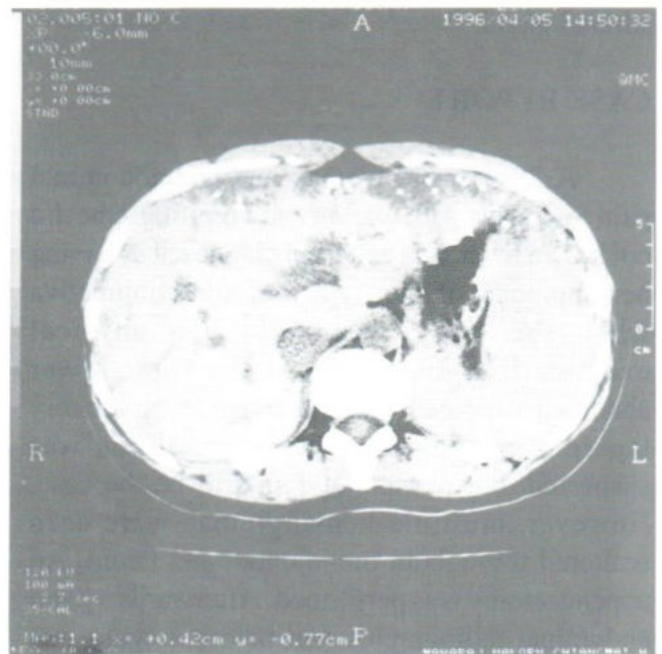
Precontrast CT scan shows multiple hypodense masses in the liver with calcifications.
